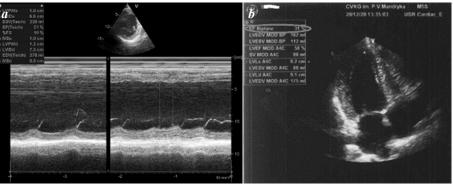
Echocardiography of a patient: a - on admission to the hospital, b - after restoration of sinus rhythm.
